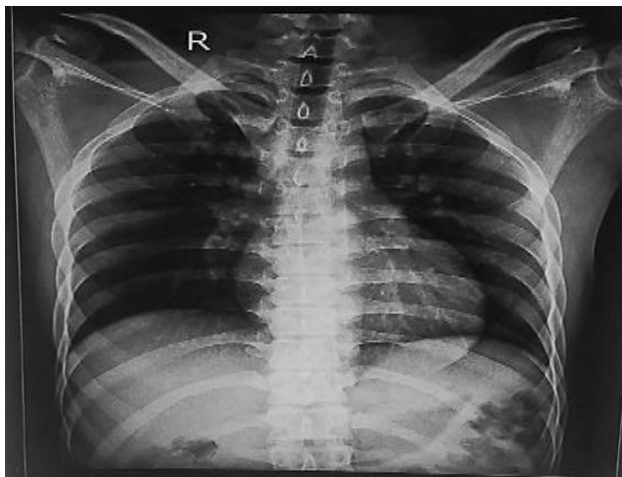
Anteroposterior chest radiograph taken at the time of admission showing no evidence of pulmonary infiltrates, effusion/other abnormalities.
